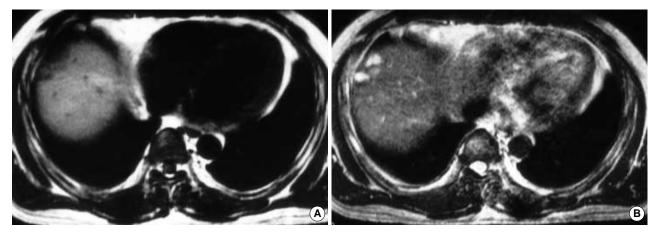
MRI of the liver demonstrate a low signal intensity lesion on T1-weighted image (A) at the same site as that at CT and a cluster of small bright signal intensities on T2-weighted image (B), suggestive of cystic nature.
